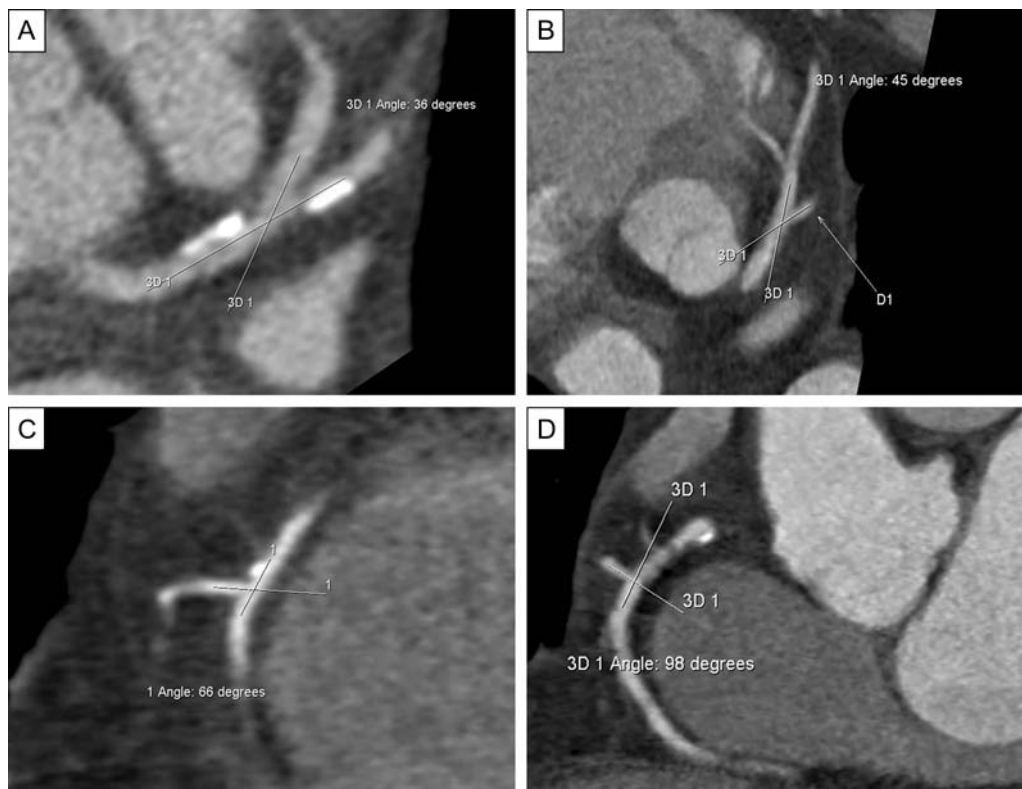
Coronary bifurcation angle measurements with MDCT. Multipolar reconstructions were rendered exactly in the plane described by the main vessel and side branch at the bifurcation site. Examples of the bifurcation angles between LAD and D1 (A, 36° and B, 45°) and between RCA and RVB (C, 66° and D, 98°). D1, first diagonal branch; LAD, left anterior descending coronary artery; MDCT, multidetector computed tomography; RCA, right coronary artery; RVB, right ventricular branch.
